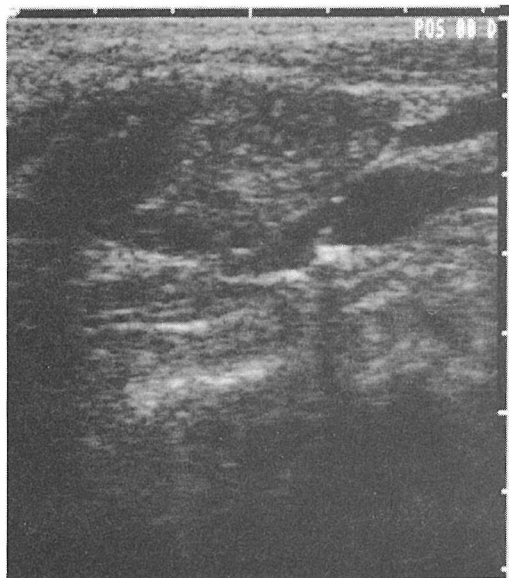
Destruction of both the internal jugular vein and common carotid artery (conventional sonography, 5 MHz).
